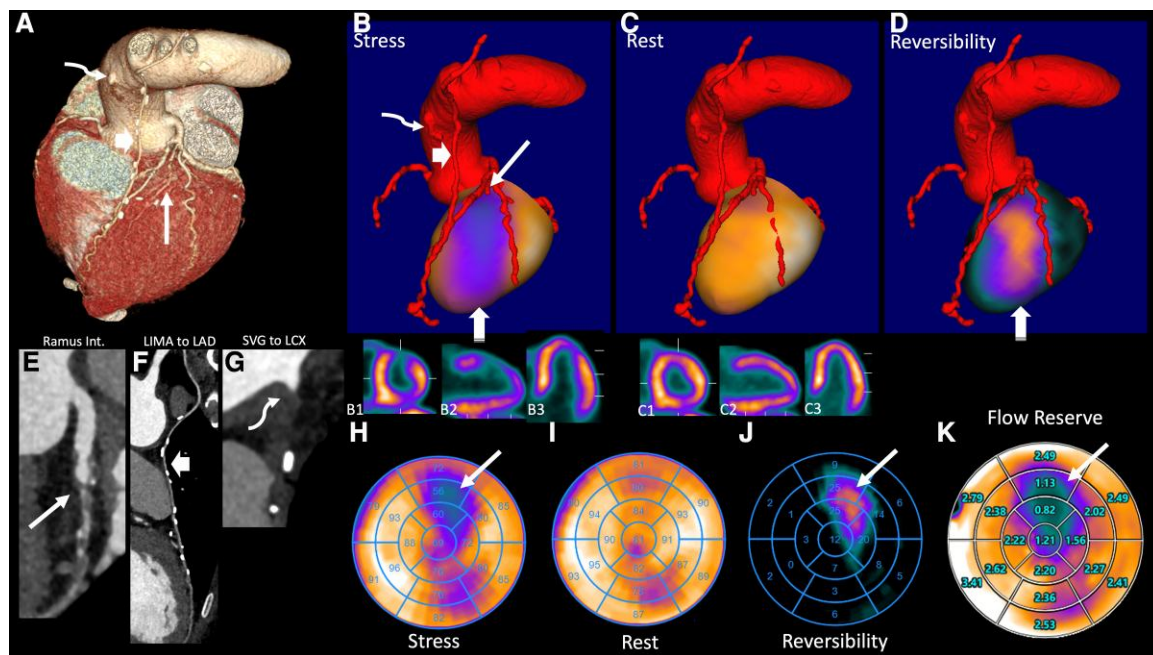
Coronary computed tomography (cCT) (A) showed recurrent occlusion of the vein graft (curved arrow), patent LIMA–LAD graft (thick arrow), and severely stenosed ramus intermedius (RI) (thin arrow). Hybrid 3D positron emission tomography (PET)/cCT fusion images (B: 3D hybrid fused stress; B1–3: stress slices; thick arrow: LIMA–LAD graft, curved arrow: occluded vein graft, thin long arrow: RI, bottom arrow: anterior ischaemia; C: rest, C1–3: rest slices, D: reversibility) identify that the ischaemia matches to the territory of the RI. The PET (H: stress polar plot, I: rest, J: reversibility) showed significant anterior and minor inferolateral ischaemia and reduced myocardial stress flow and flow reserve (K: flow reserve polar plot) in the anterior wall. The cCT with severely stenosed RI (E), patent LIMA–LAD (F), and occluded vein graft (G).
